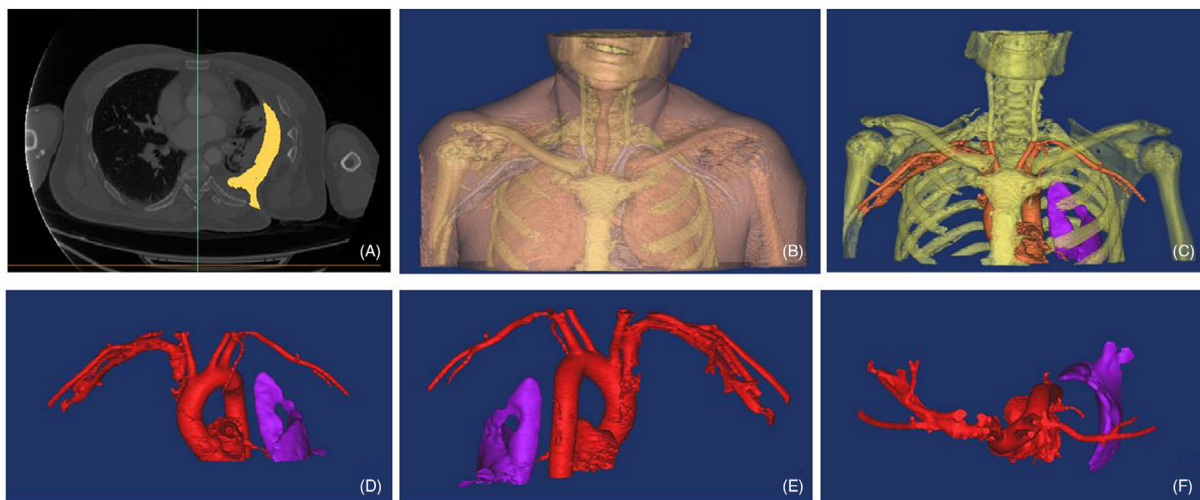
Three-dimensional (3D) reconstruction image of post-pneumonectomy empyema with bronchopleural fistula before surgery. (A) Computed tomography (CT) slicer shows the empyema cavity and bronchial fistula (bright yellow part); (B) anterior view of the patient after 3D reconstruction based on CT data; (C) perspective view of the patient: yellow part-bone; red part-angiography; purple part-empyema cavity; (D-F) the relationship between the empyema cavity and important vessels from the anterior, posterior, and superior views
